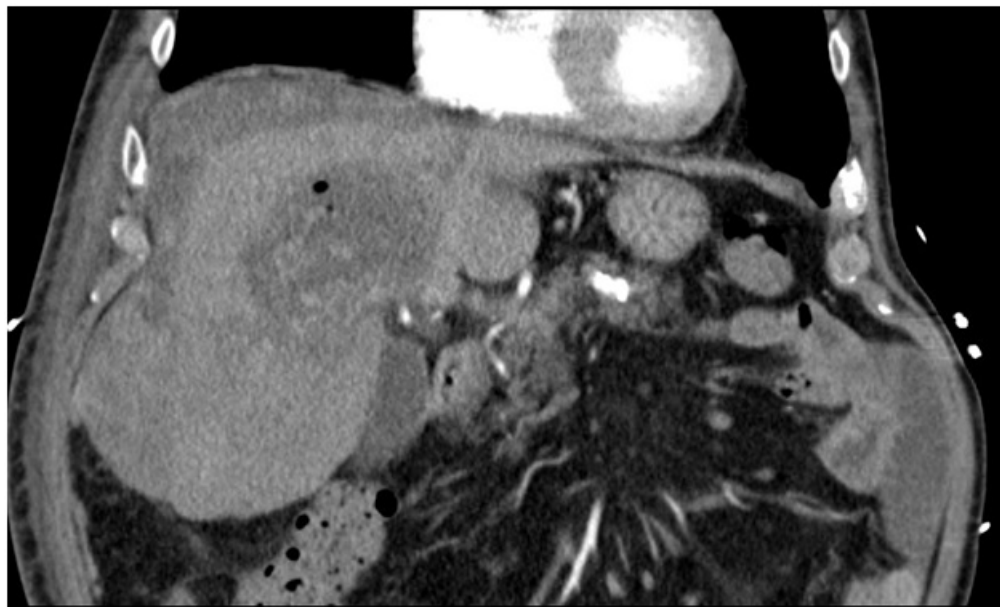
CT scan of liver abscess after successful drainage.
